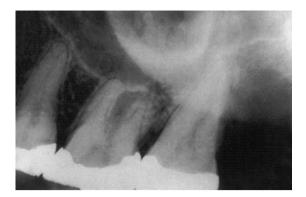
Periapical radiograph of the maxillary right region showing the periodontal defect on tooth 27.
